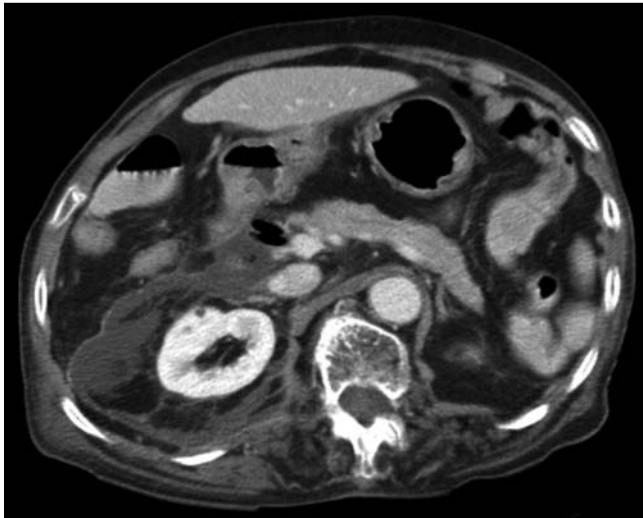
Abdominal computed tomography (CT) scan showing a large, irregular fluid collection with rim enhancement in the entire right pararenal space, and free air between the second part of the duodenum and the pancreas head.
